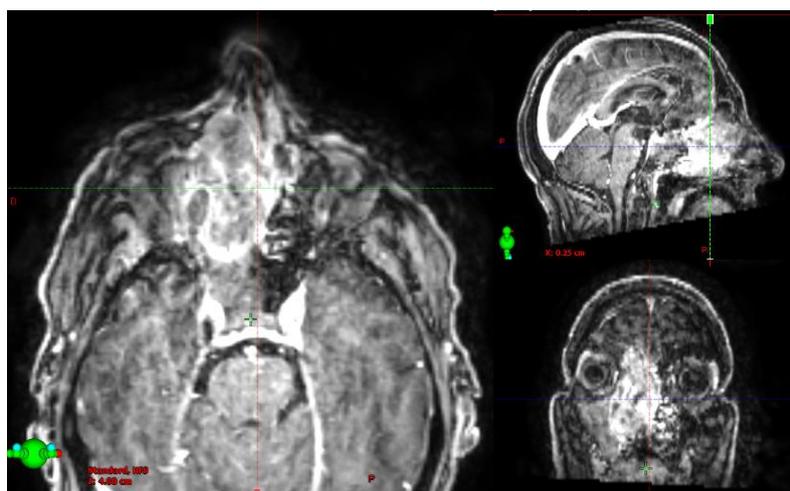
T1 cervicofacial MRI with gadolinium injection, showing a massive endonasal and ethmoidal lesion extended the maxilla, the frontal sinus, the medial wall of the orbit, with an infiltration of the cribriform lamina and meningeal irritation
